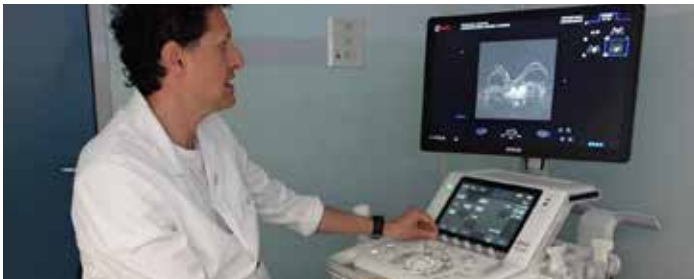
BreastNav™ MRI fusion imaging between US and MRI, in real-time investigation
